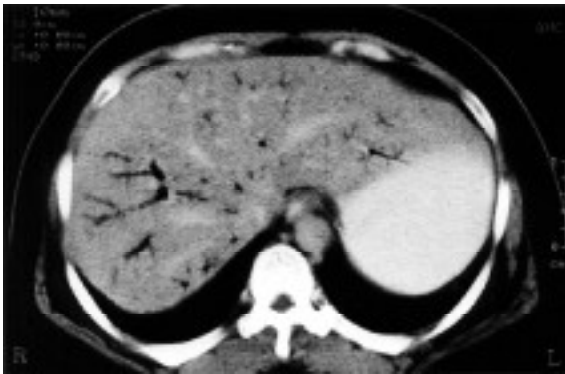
Enhanced CT scan of the abdomen taken at the level of the upper liver.
